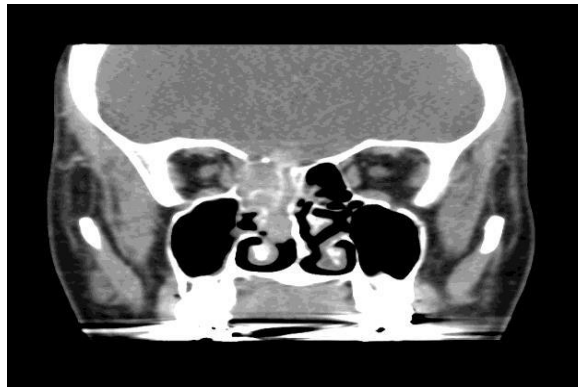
shows coronal CT image soft tissue with esthesioneuroblastomas (<https://radiopaedia.org>)
